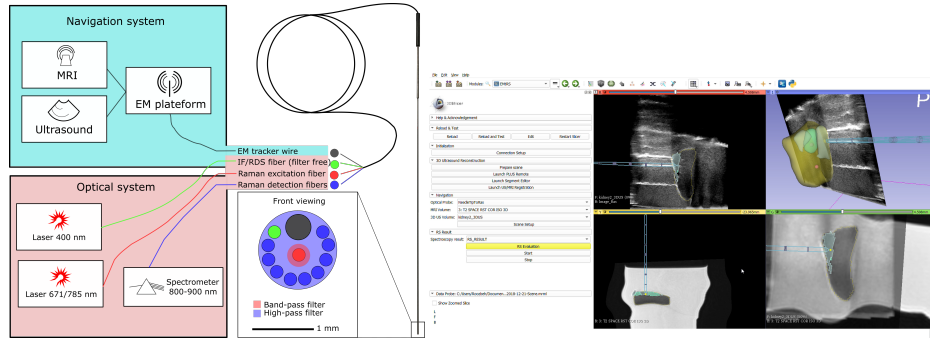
Left: Components of the system. Right: Screenshot of the navigation environment and visualization of results. Top left: Live 2D ultrasound with the location of the optical probe. Top right: Segmented targets (calyx, medulla and cortex), results of RS, location of the optical probe and ultrasound. Bottom left: Deformed MRI. Bottom right: Deformed MRI in sagittal view.
